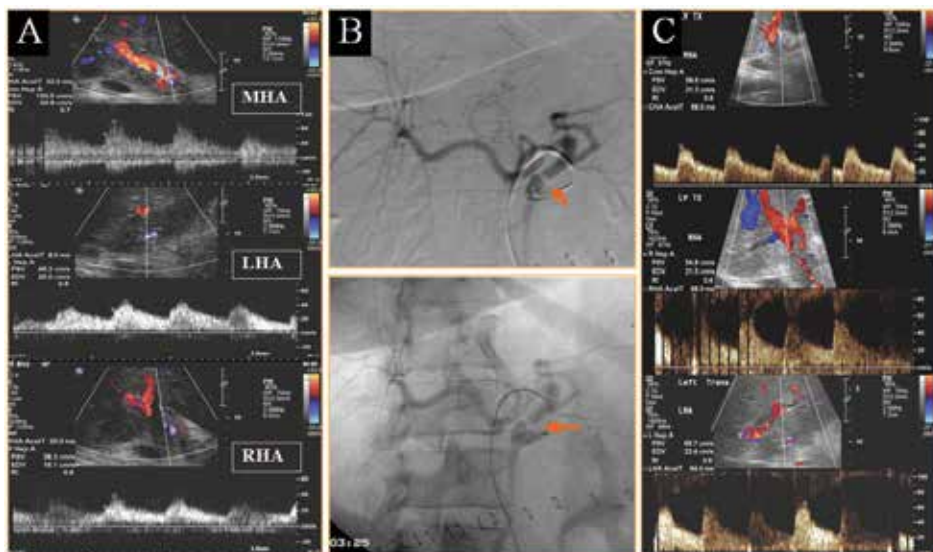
Early hepatic arterial stenosis (Surgically treated). (A) Doppler US performed day 5 post liver transplant shows tardus parvus waveform and low acceleration times in the right, left and main hepatic arteries. (B) Catheter angiogram, subtracted and un-subtracted images, confirms the stenosis at the proper hepatic artery. (C) post surgical revision follow up Doppler US reveals normal hepatic arteries wave forms
